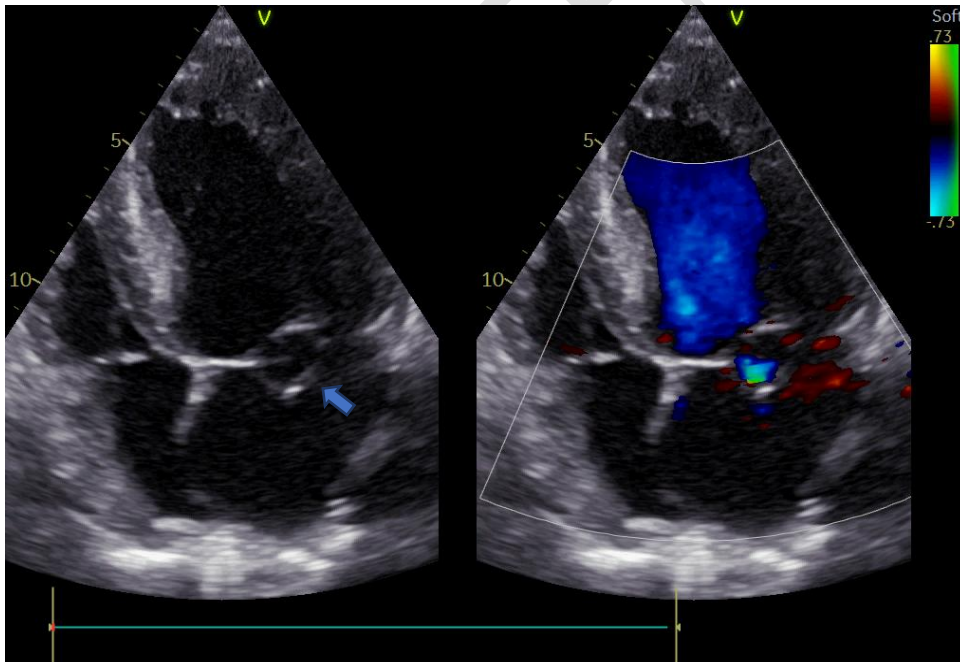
Transthoracic echocardiography showing fistulized abscess of the anterior mitral leaflet
